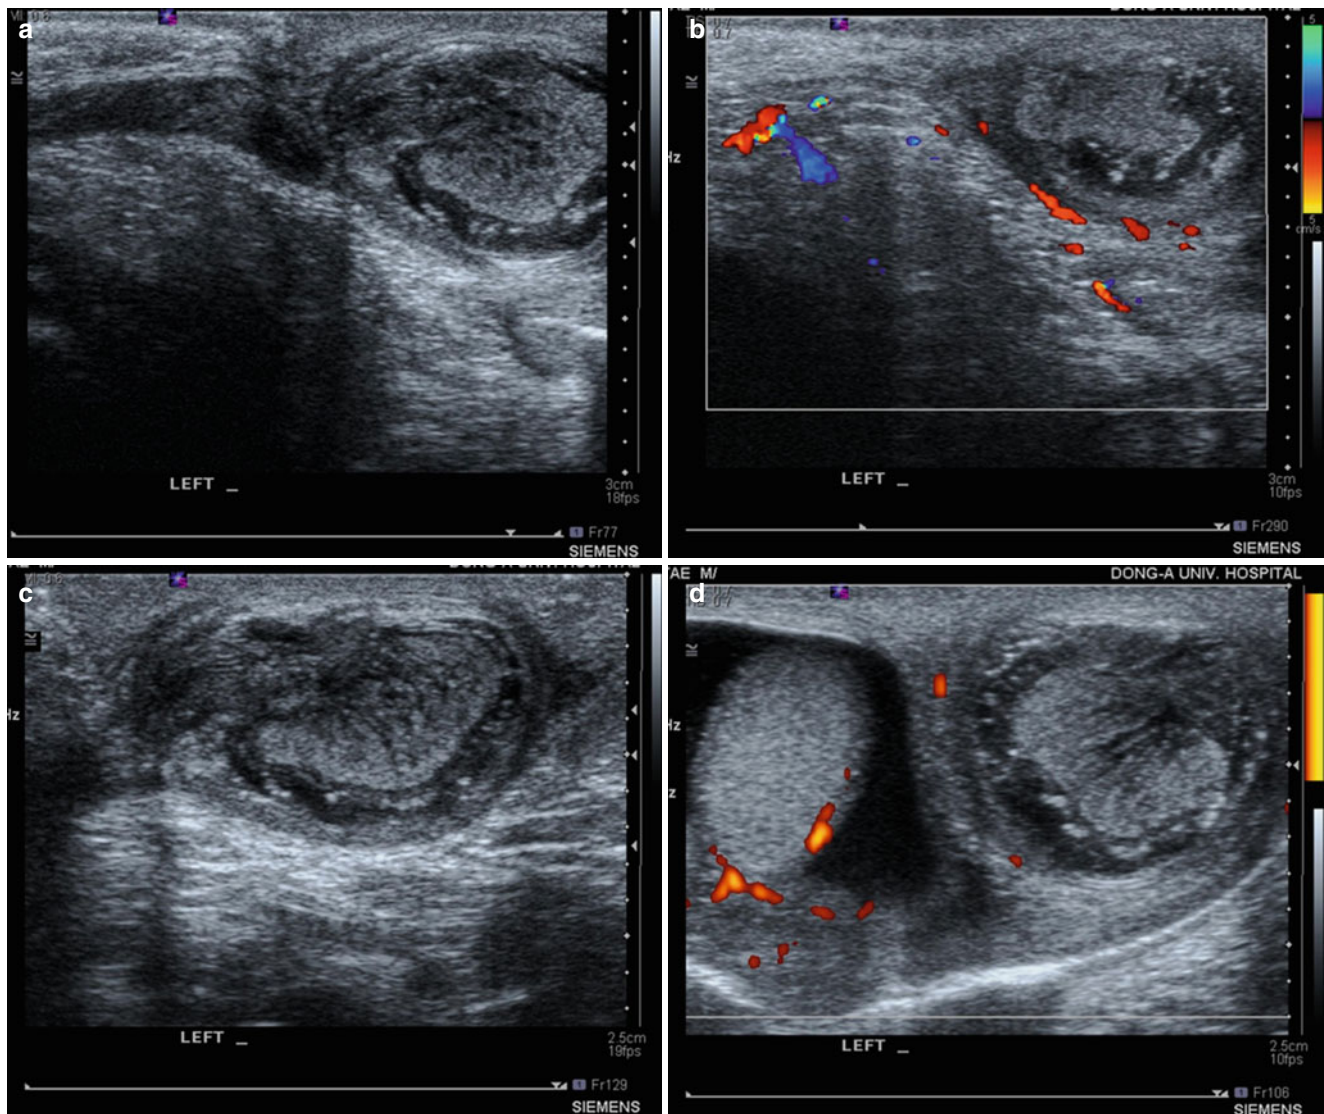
Extravaginal testis torsion of the left testis in an infant. Longitudinal (a) and transverse (c) US scans of left scrotum show heterogeneously enlarged testis and torsion knot in spermatic cord, representing outside the tunica vaginalis. Color Doppler images (b, d) reveal
